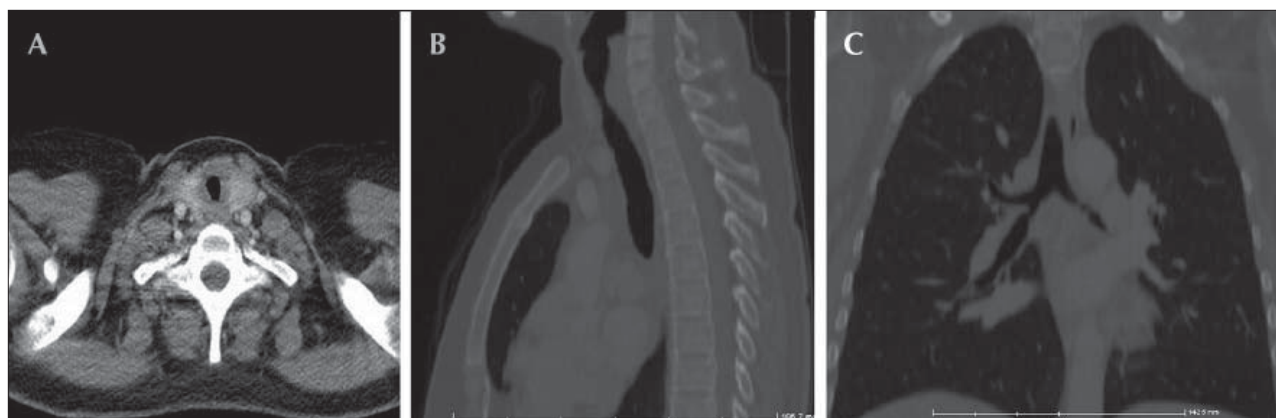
Thoracic CT sections. (a) Stenosis in the subglottic region in the transverse section. (b) Stenosis in the sagittal section is observed to be on a segment that is approximately 2 cm long. (c) Stenosis is observed in the left main bronchus in the coronal section.
